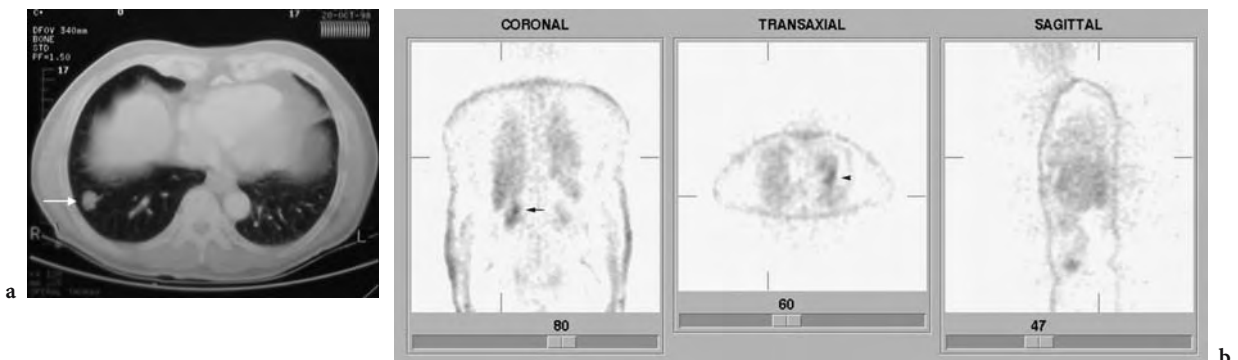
Solitary pulmonary nodule. a Transverse CT image shows a nodule in the right lung base (arrow). b Transverse, coronal, and sagittal PET images do not reveal increased metabolic activity in this area. This 63-year-old white male had a positive skin test, and the lesion was thought to be a tuberculoma. No biopsy was performed and conservative treatment selected with repeat CT. Note the physiologic uptake in the right renal pelvis (arrow on coronal image), and myocardium (arrow on transaxial image). Cross sectional CT slice of 8 mm obtained with a PQ 5000 system (Picker, Cleveland, OH). PET slices of 10 mm from ECAT ART system (CTI, Knoxville, TN) reconstructed without attenuation correction
